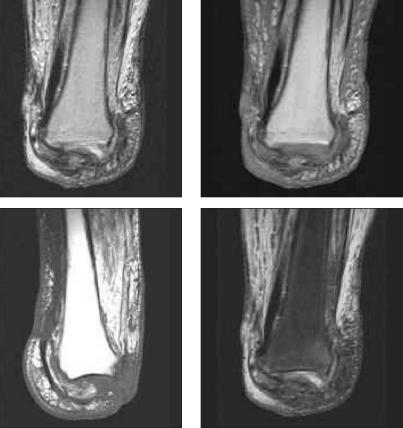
These MRI images below demonstrate the Syme amputation. Note the tissue from the heel forming a pad at the distal stump. This is the principle advantage of this procedure due to the more effective weight bearing.
